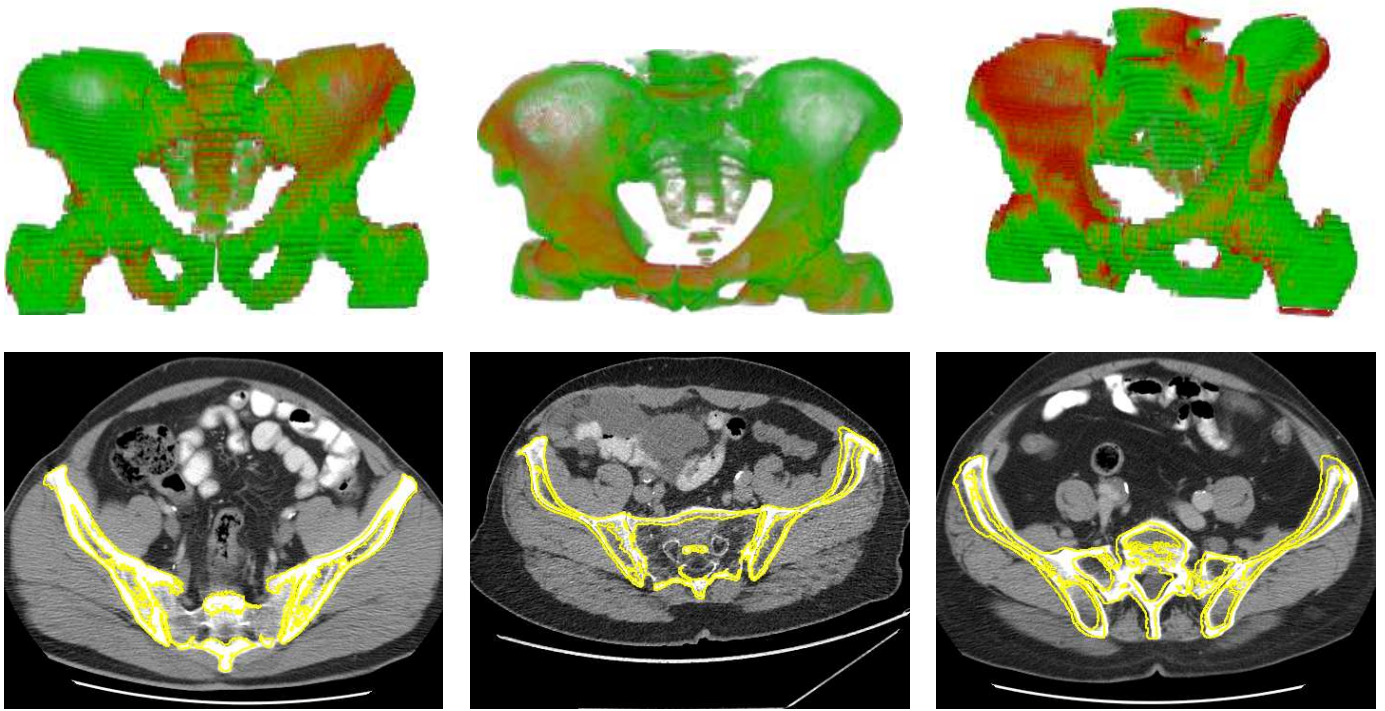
Registration of pelvic CT data: superimposed registered 3D bone models (top row), and bone contours of the registered template (yellow) overlaid on a CT slice of the observations (bottom row). δ errors are 14.2%, 19%, and 27.87%. The first two cases show good alignment. Even the third one can be regarded as a fast, coarse approximation.
